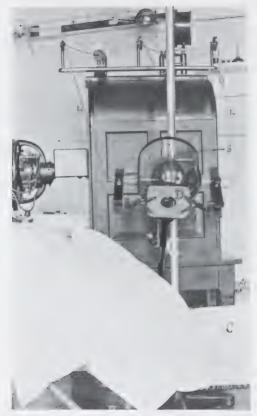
Showing one of the *essential* means of protection of the patient during a therapeutic exposure. It is always advisable to have the patient lying down on a couch, C, or table, when any parts, except possibly the extremities, are being treated. The thick lead glass tube shield, S, serves to cut off most of the rays laterally, though such a device is by no means an absolute protection against exposure, and does not preclude the possibility of the hair of the scalp coming out. It further serves to protect from any dangers arising from the possible collapse of the tube. An adjustable lead diaphragm, D, at least $\frac{1}{2}$ in. in thickness, should always be used when the area treated is small, and the aperture should be no larger than is necessary for the exposure of the area under treatment. The surrounding healthy parts may be further protected by lead foil, especially during the treatment of any portion of the face or head. When the skin is intact, the exposed area should be covered by some form of x-ray filter, such as thin aluminum, thick leather gauze, or the clothing, unless the most superficial radiation, as of the skin itself, is desired.
